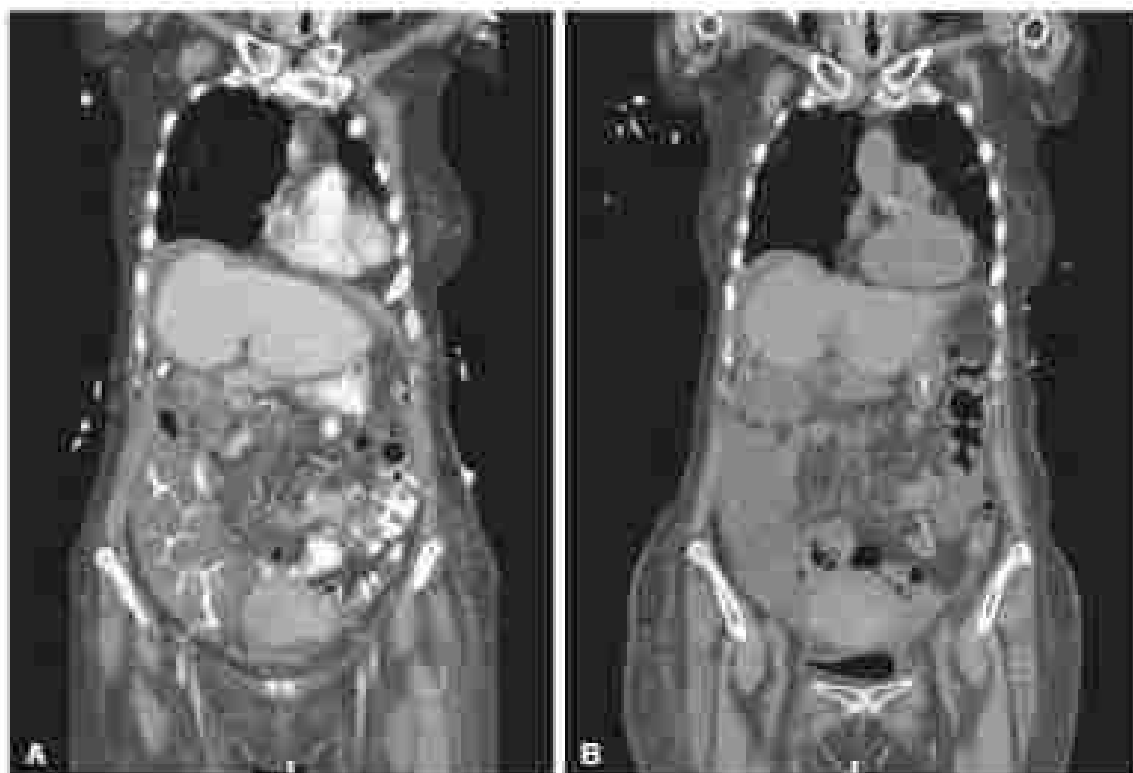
Coronal computed tomography scan showing fulminant *Clostridium difficile* infection of the right colon. (A) With contrast versus (B) without contrast reveal the importance of contrast utilization with imaging for diagnosis.
